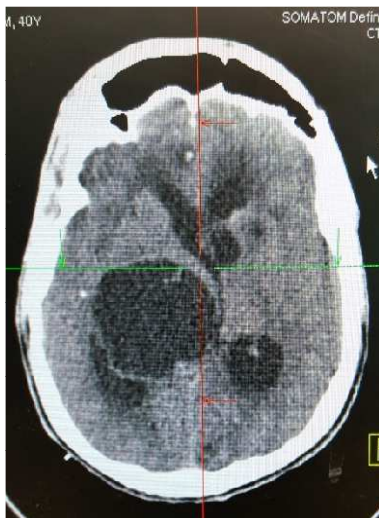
Neurocysticercosis type 1. Vesicular type. Patient M/40, with seizure. Multiple neurocysticercosis lesions of type 1, vesicular type, with lesions of target type in the brain. Pre-contrast CT of the brain reveals a large vesicle in the right lateral ventricle, in which scolex is not evidently found.
